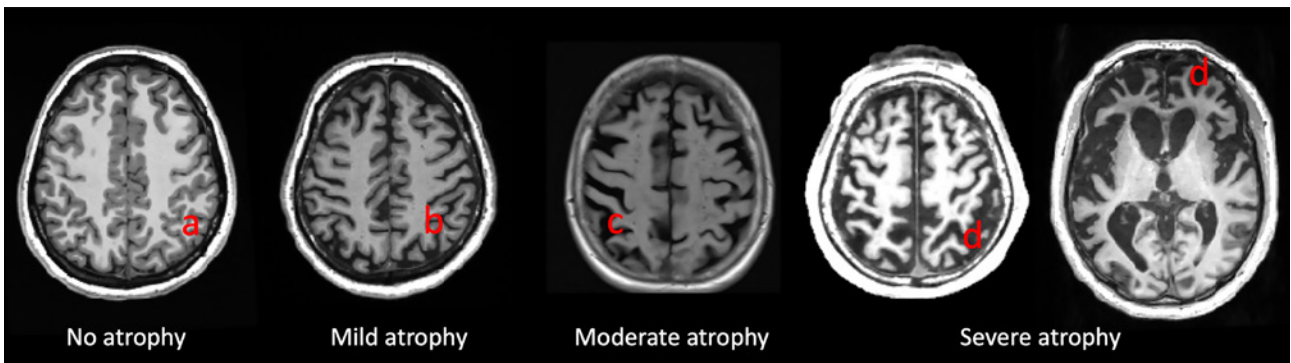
Representation of a series of T1 weighted MRI showing cortical atrophy depicting normal (a), mild (b), moderate (c), and severe (d) cortical atrophy, respectively.
